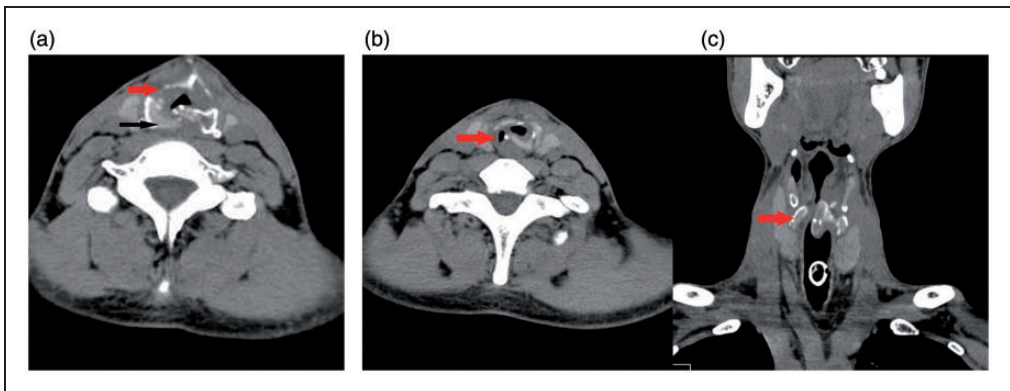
Computed tomography examination. Fractures were present in (a) the right thyroid cartilage (red arrow) and posterior arc of the cricoid cartilage (black arrow). (b, c) Stenosis was present in the subglottis and first and second tracheal rings.
